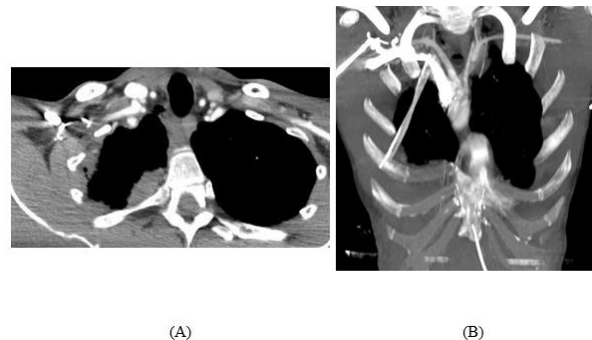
(A and B). CT-scan demonstrated active bleeding signs from right subclavian artery, but without precise location.
